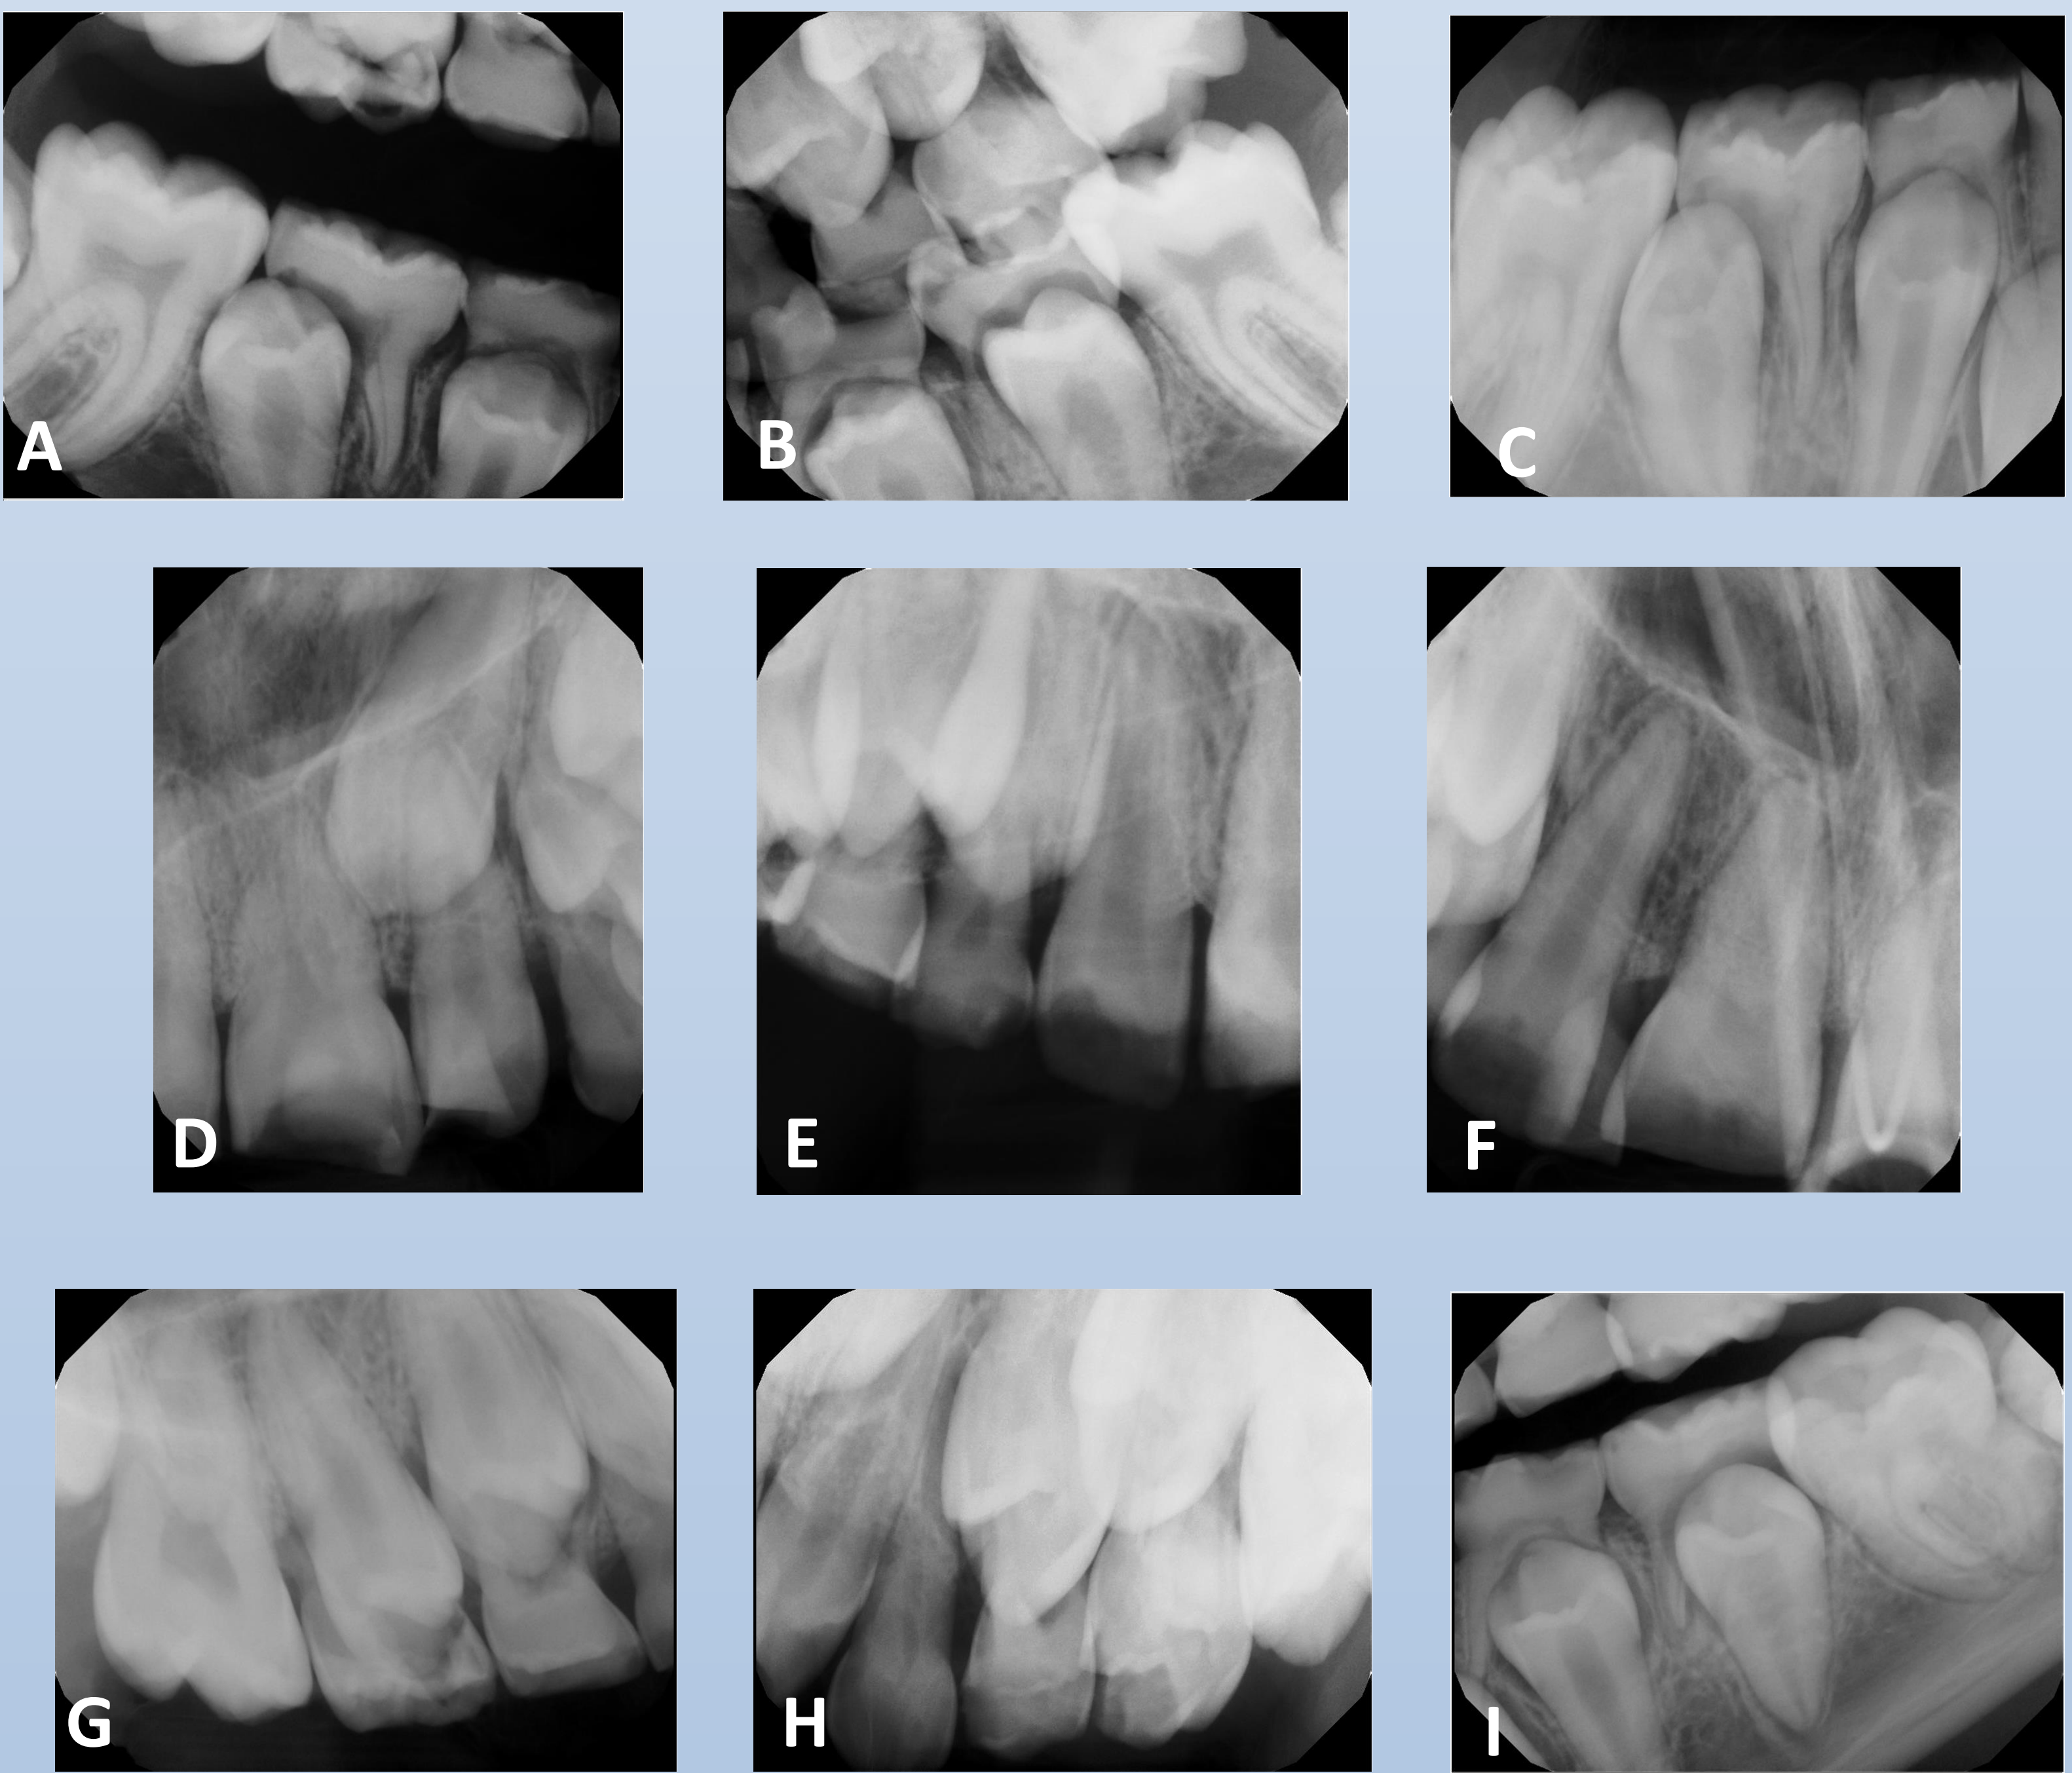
A-B Intraoral bitewings taken on 12/12/2024. C-I intraoral periapical radiographs on posterior and anterior regions.
